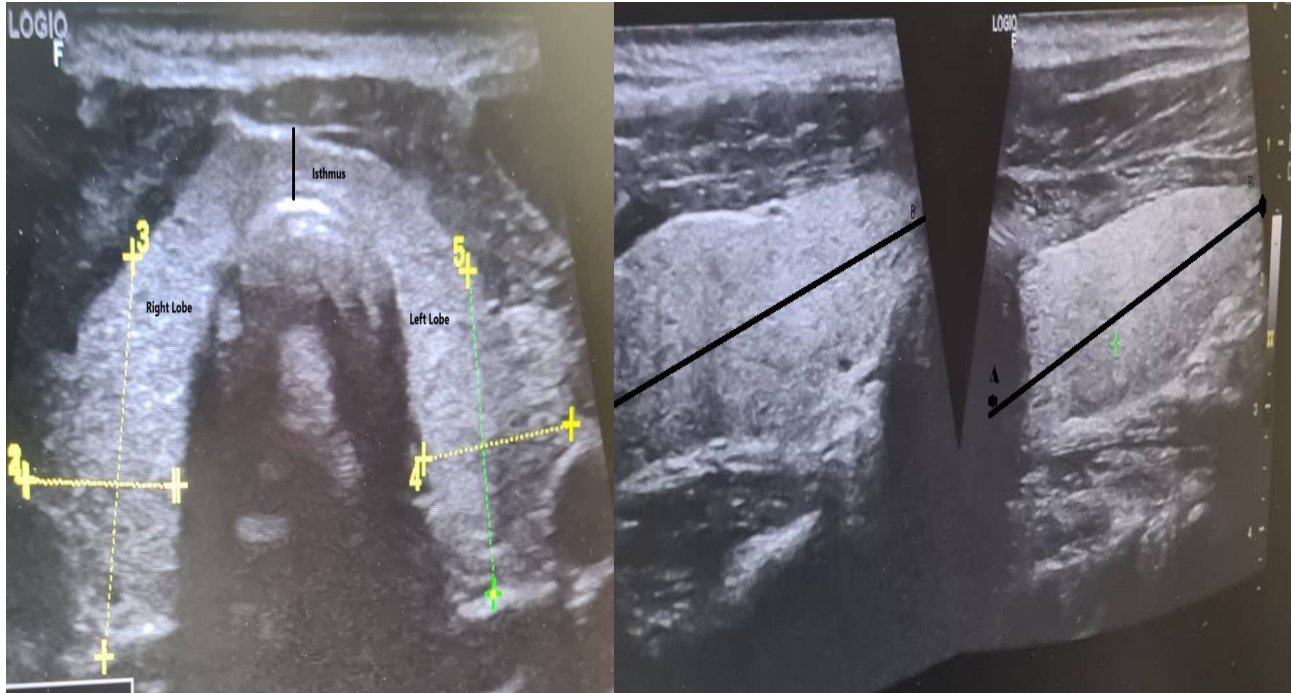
Ultrasound scan of the thyroid showing the lobes and the isthmus.
